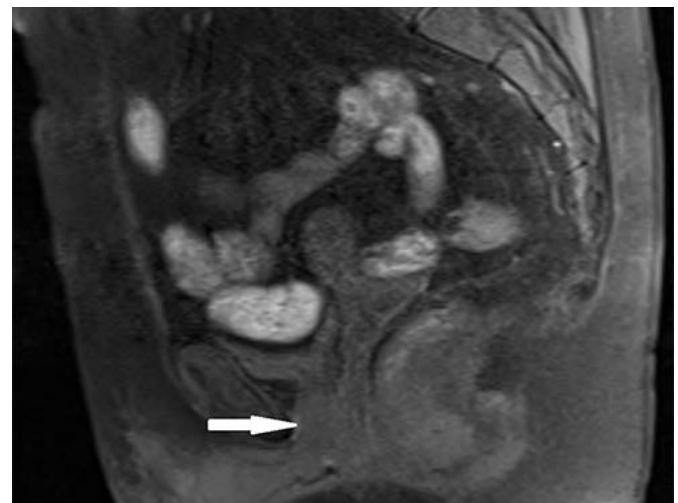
MRI findings in vulvar cancer with distal urethral involvement: Sagittal section of the MRI image, highlighting distal urethral involvement (white arrow)
